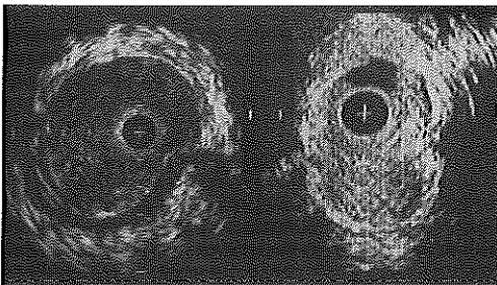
Intravascular ultrasound cross-sections showing a patent end-to-end anastomosis (left panel) and an "insufficient" end-to-side anastomosis (right panel). In both panels the vein wall is at the top; the arterial wall is seen at the bottom as a three-layered wall with a hypochoic middle layer representing the tunica media. The lumen in the right panel is severely obstructed by a soft lesion. + = Catheter; calibration = 1 mm.
